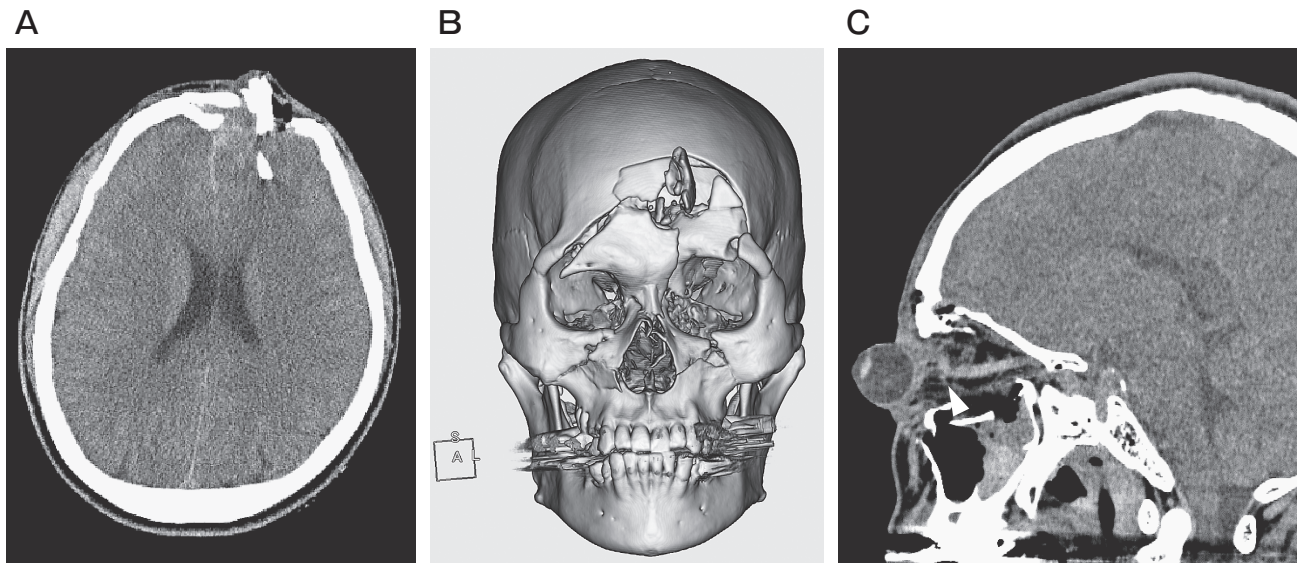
Computed tomography scan showing depressed frontal bone fractures with underlying cerebral contusion (A), pyramidal fractures involving the maxilla, nasal bones, and inferior orbital rim, which were classified as Le Fort II (B), and right optic nerve transection in the sagittal view (C, arrow head).
